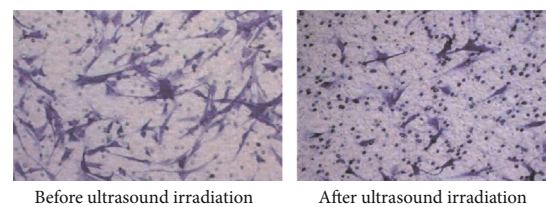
Representative views of VSMCs migrating from the uncoated upper chamber into the lower one before and after ultrasound irradiation.
